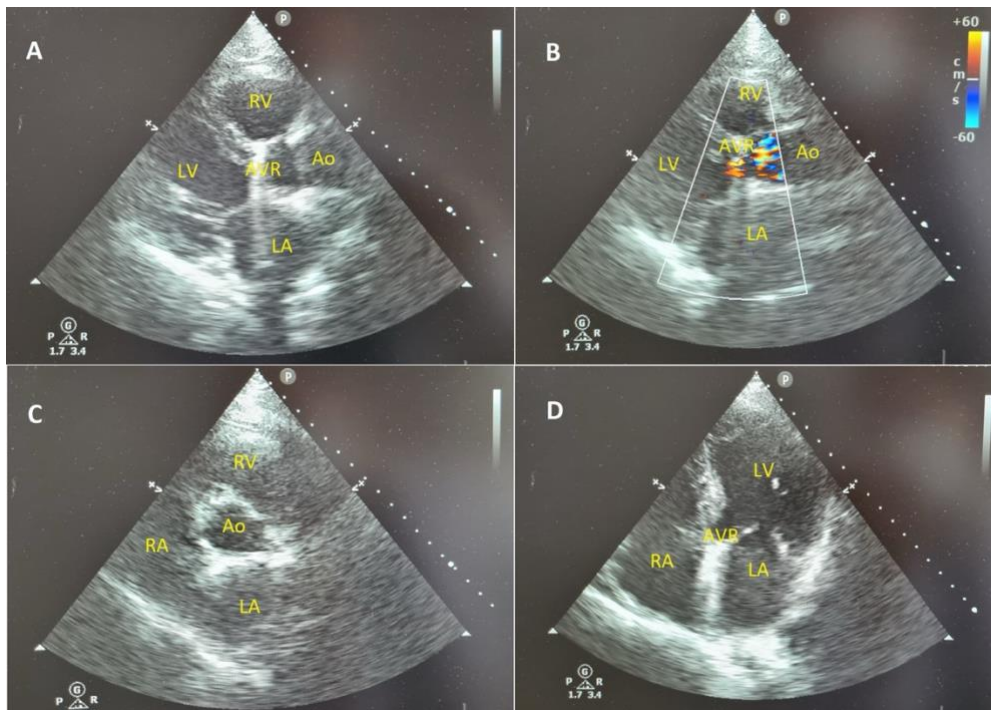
Postoperative transthoracic echocardiographic images of the patient. A. Parasternal long axis 2D image, B. Parasternal long axis color Doppler image, C. Parasternal short-axis image, D. Apical four-chamber image. Ao, Aorta; LA, left atrium; LV, left ventricle; RV, right ventricle.
